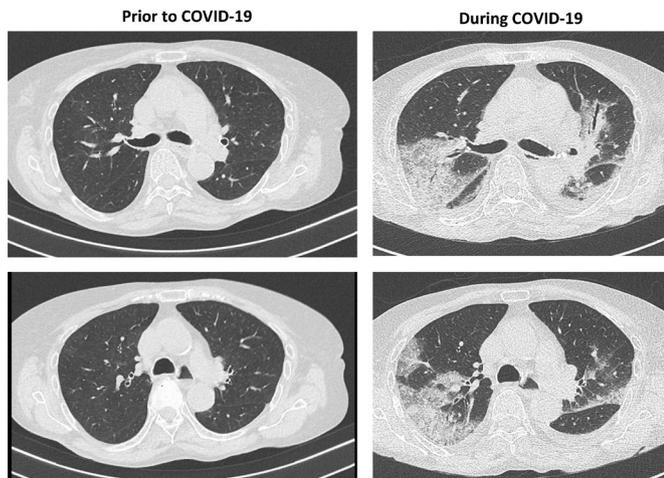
Representative images of chest high-resolution CT scan performed of patient 2, showing no pre-existing systemic sclerosis-associated interstitial lung disease and typical bilateral interstitial pneumonia related to COVID-19.
